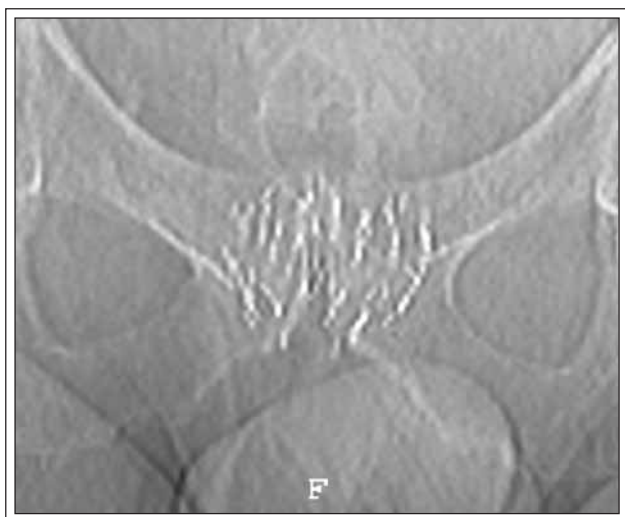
A computed tomography scout image of an I-125 seed implant using custom-made links of connected seeds using the QuickLink device (C.R. Bard, Inc., Covington, Georgia, USA) push-button delivery system.
